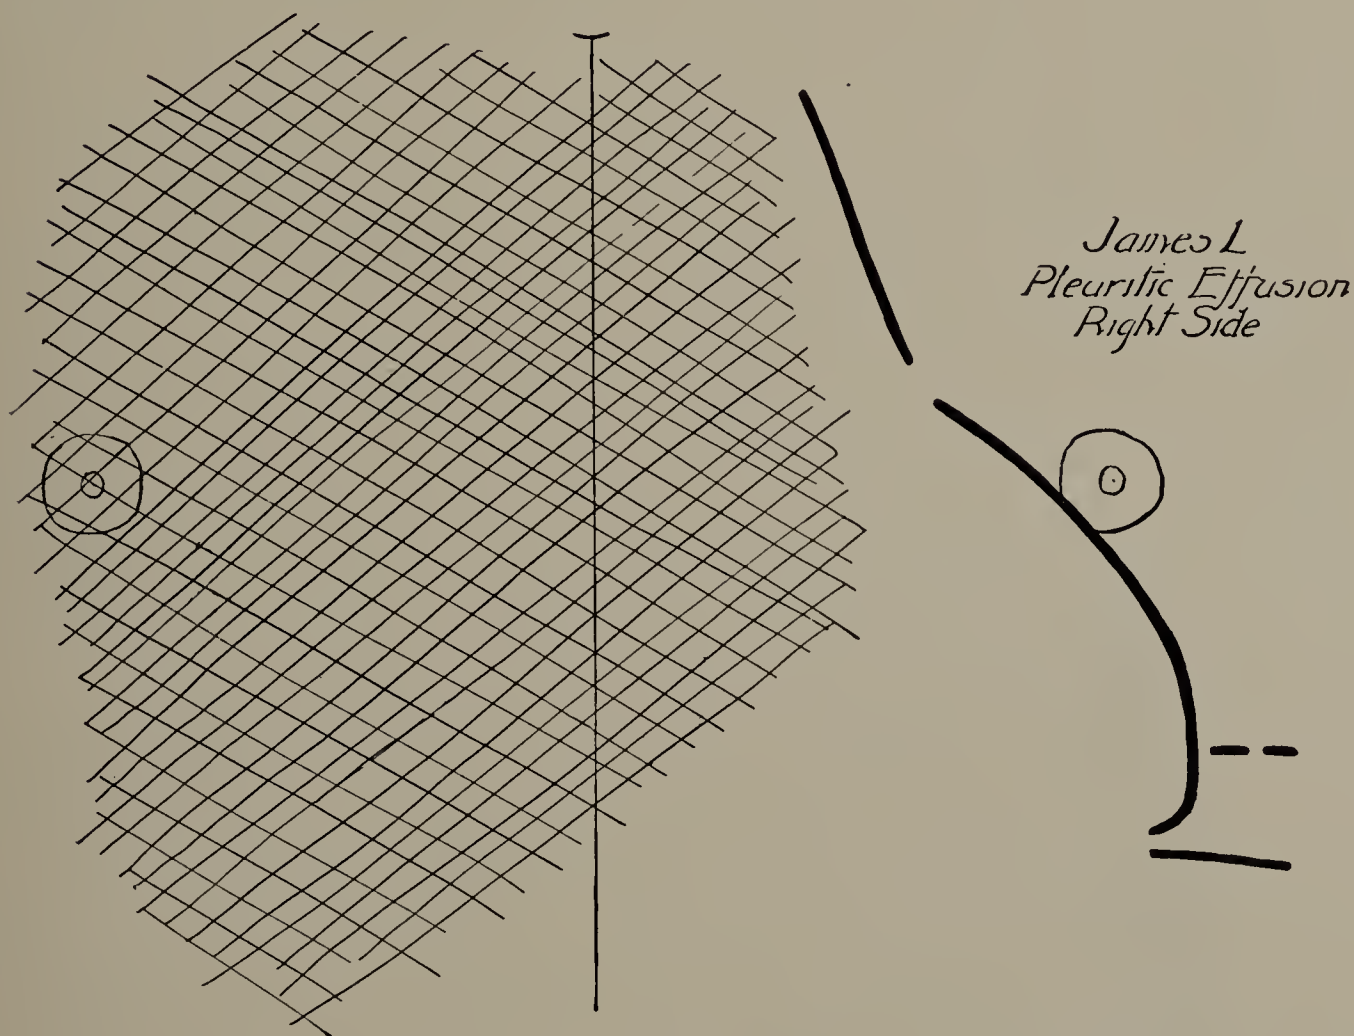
James L. February 13. Cut of X-ray tracing. Pleuritic effusion on right side. Heart and contents of mediastinum displaced to left. Diaphragm on left side pulled down and excursion limited, as indicated by broken line and full line below it. (Cut one-third life size.)
